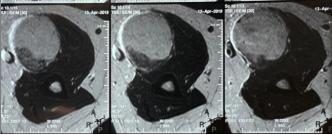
MRI showing schwannoma of high signal Intensity in T2 weighted images.
